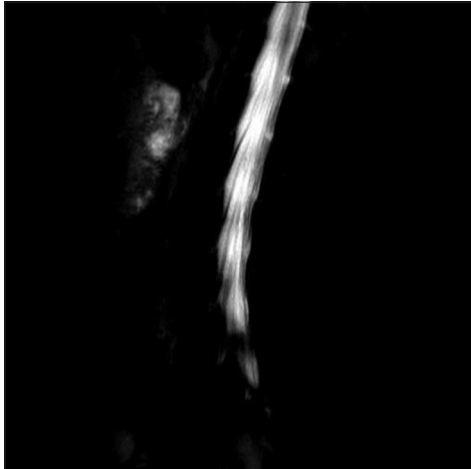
Myelographic magnetic resonance imaging sequence demonstrating complete “obstruction” at L5S1.
